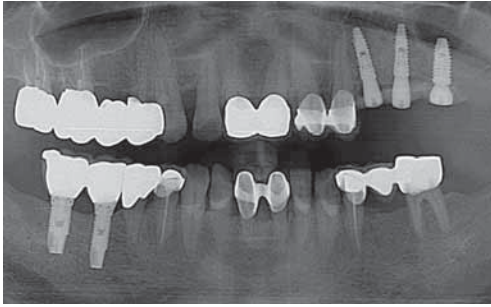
Panoramic radiograph taken after stage II surgery.
